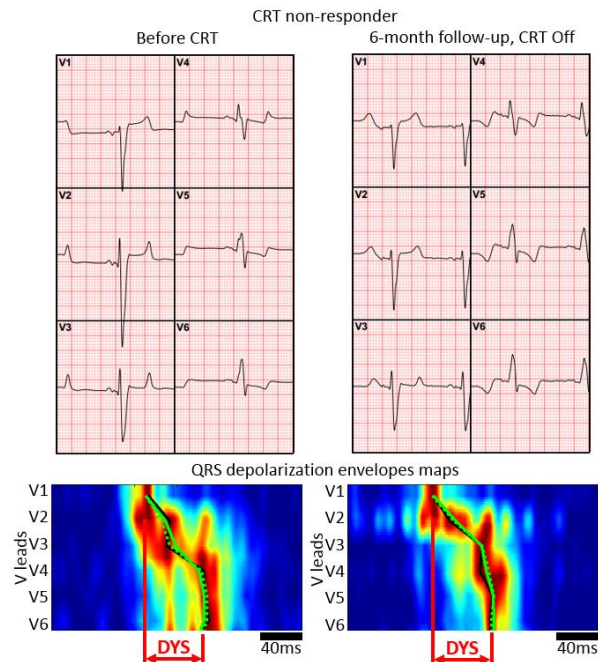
Example of the CRT non-responder by echocardiography (no change of ESV); with almost no change of QRSd (157ms to 160ms) and DYS (61ms to 58ms). QRS depolarization envelopes maps are created by amplitude normalization over the V lead envelopes (max. amplitude – red, min. amplitude – blue color), arranging envelopes into rows from V1 to V6 and performing a linear interpolation between the rows.
